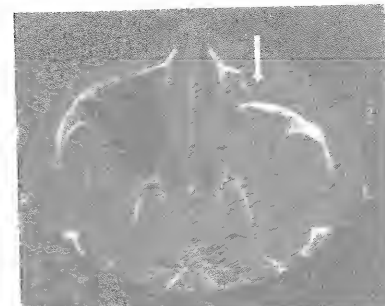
CT scan showing a depressed fracture of anterior wall of left maxillary antrum.
